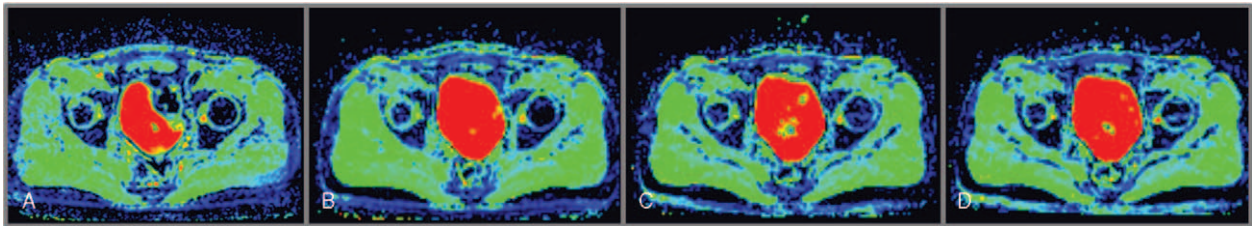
Exemplary ADC maps corresponding to the DWI images in Fig. 1A–D. ADC=apparent diffusion coefficient, DWI= diffusion weighted sequences.
